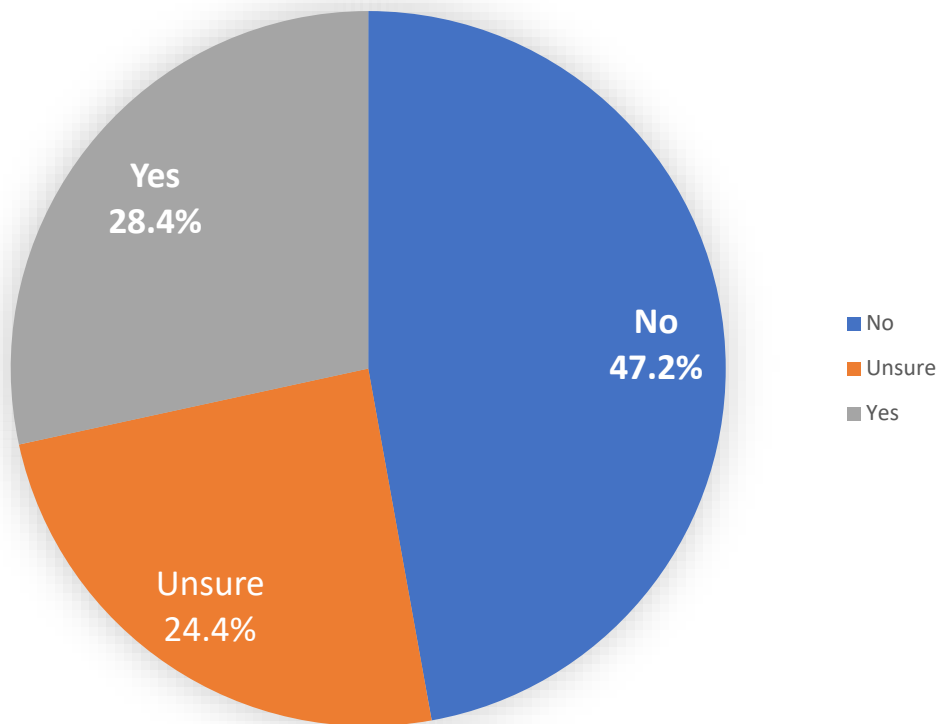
Sonographers' perceived adequacy of employer-provided mental health and wellbeing support. Responses indicate whether participants felt their employer provided sufficient support resources ("Yes"), insufficient support ("No"), or whether they were unsure about the availability or adequacy of such support ("Unsure").
